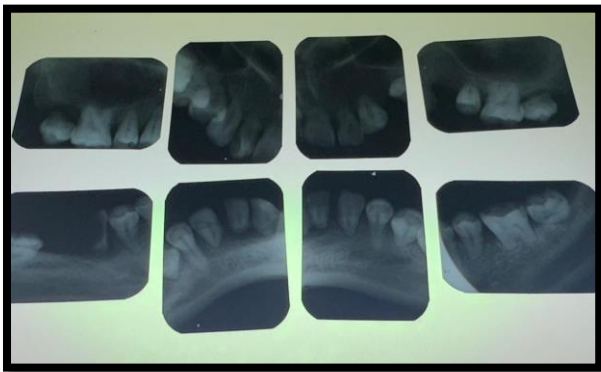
3 (Full mouth intra oral periapical radiograph)
